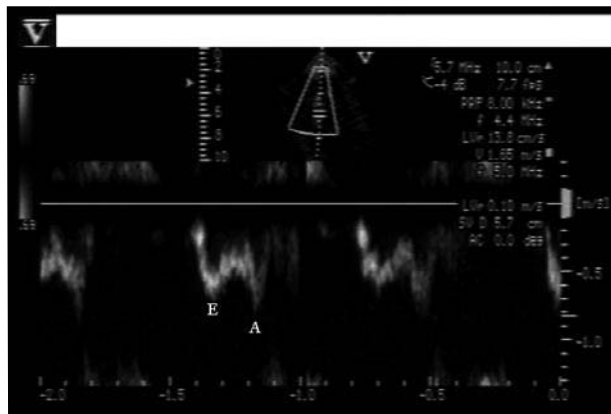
Decreased mitral inflow pulsed wave Doppler (E: A ratio < 1) during cross clamping.
